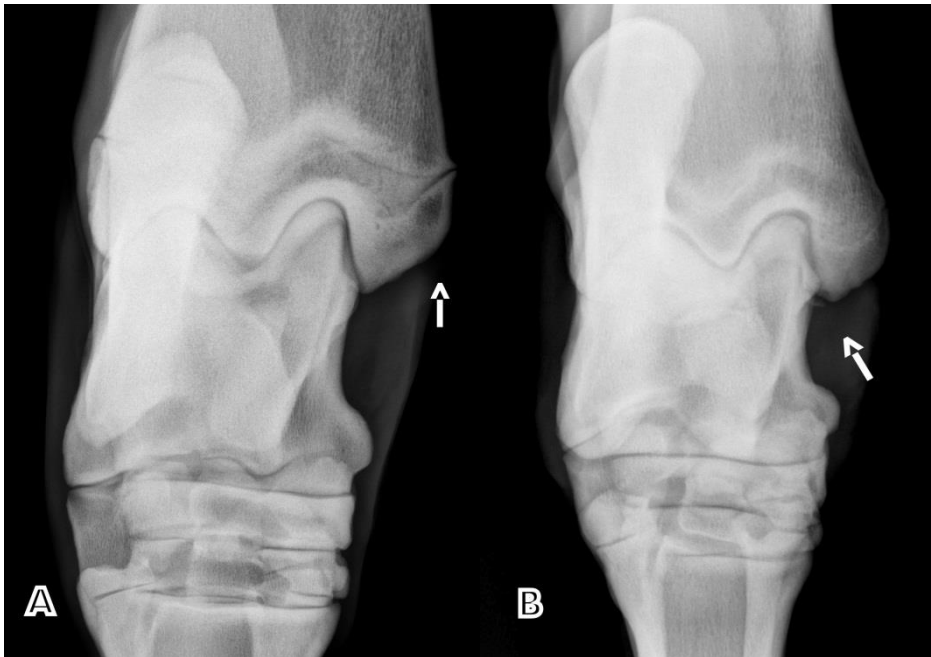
Dorso-plantar radiographic view of tarsus showing (A) lucency in the medial malleolus of the tibia (arrow) and (B) a discrete osseous opacity distal to the medial malleolus (arrow) of the tibia, both a manifestation of osteochondrosis.
